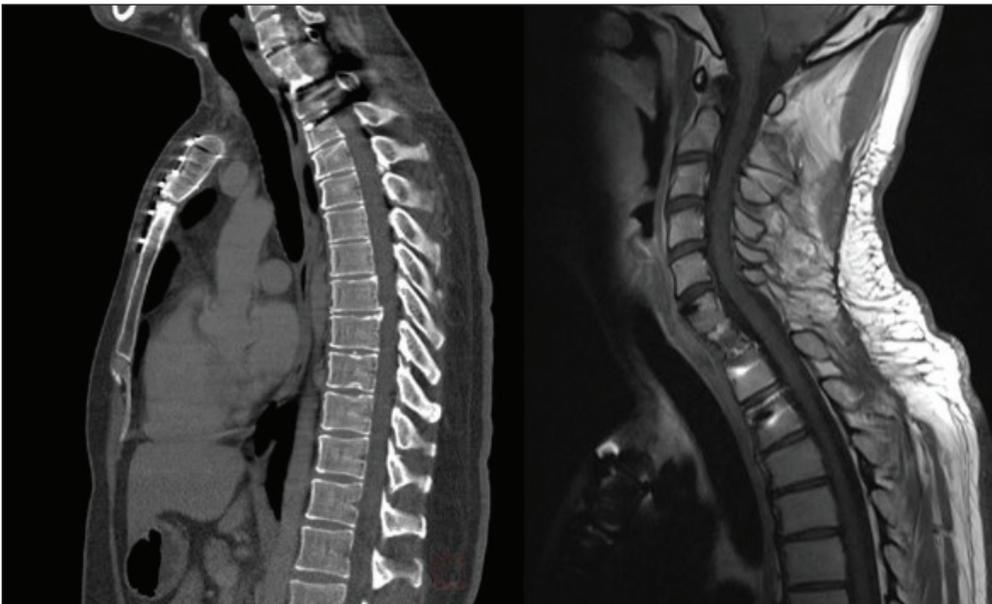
Left image: postoperative 6 month CT scan, midsagittal view in patient 1. Right image: T1-weighted contrast-enhanced MRI, midsagittal view in patient 1.
